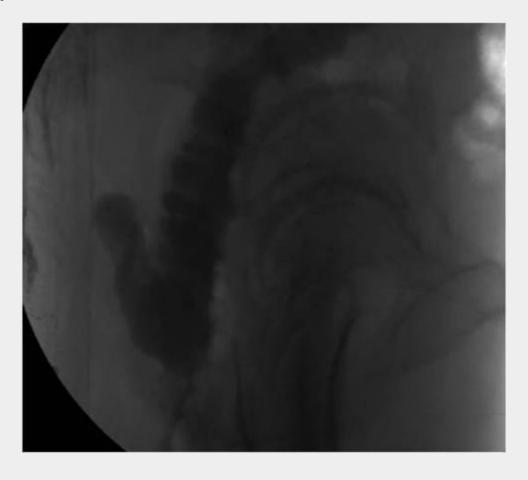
Pelvic CT of patient with an ileo-anal J pouch.
